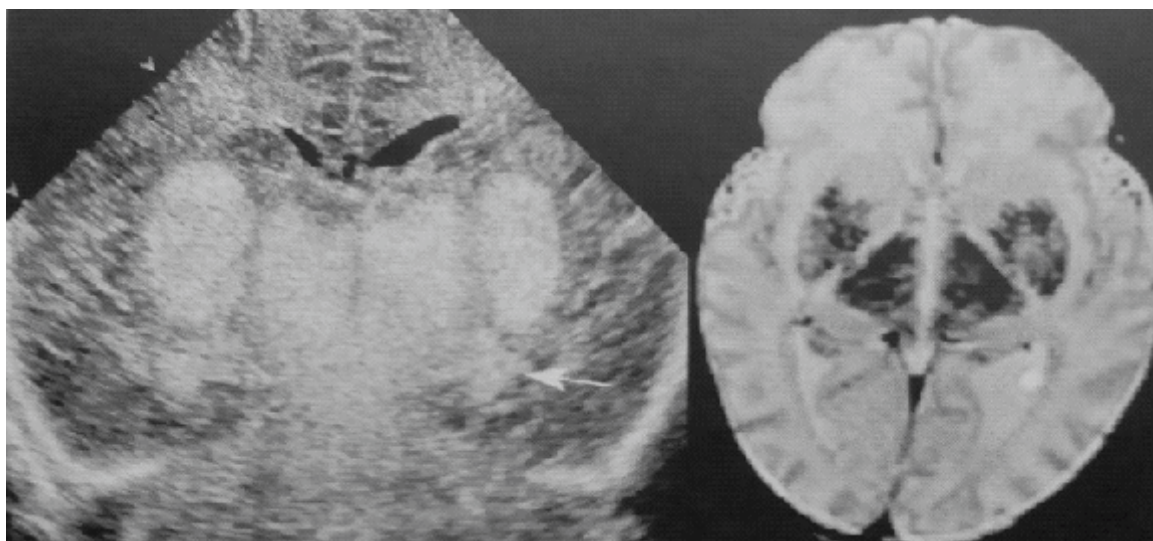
Thalamic hemorrhage as seen on CUG (left) and MRI (right)
